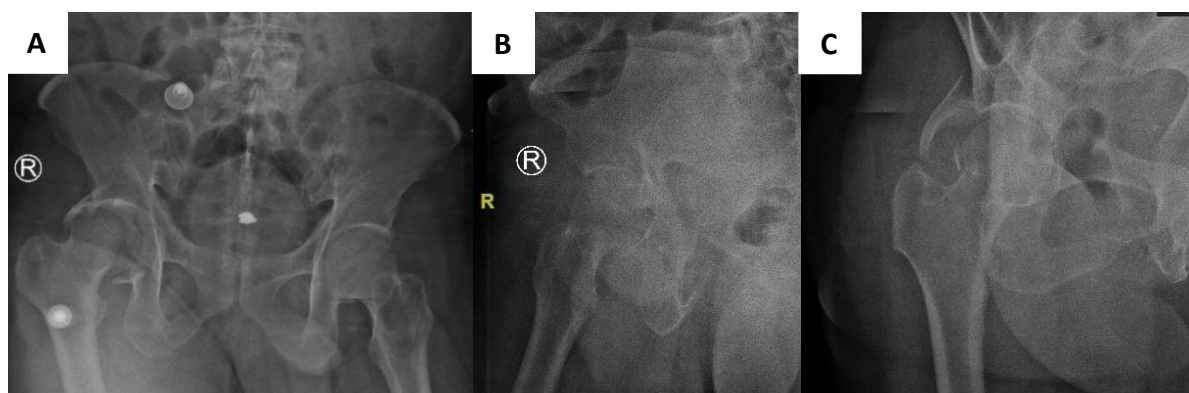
A. Pelvis Ap X-ray before ORIF, B. Alar X-ray before ORIF, C. Obturator X-ray before ORIF
